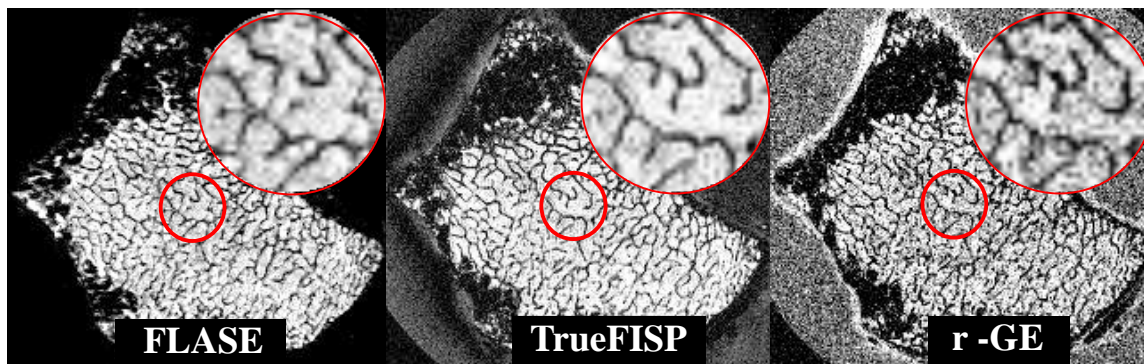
$\mu$ -MRI of intact human distal radius obtained with three pulse sequences in the same total time. Inset represents magnification of a circular ROI showing high similarity in structure. Note increase in apparent trabecular thickness in r-GE (see Table 1 above).
